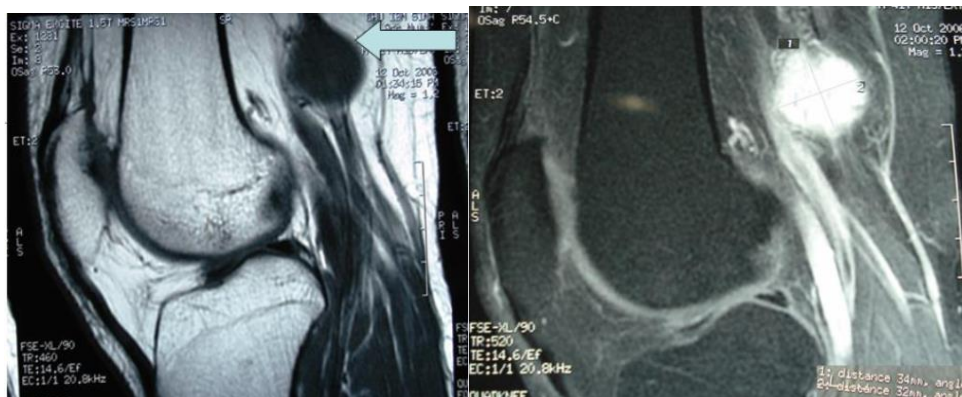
Coronal T1-weighted MRI of the right knee: a fusiform lesion with homogeneous T1 isointensity, showing enhancement after gadolinium injection. The lesion measures 34 × 32 mm and displaces the sciatic nerve at its distal aspect
